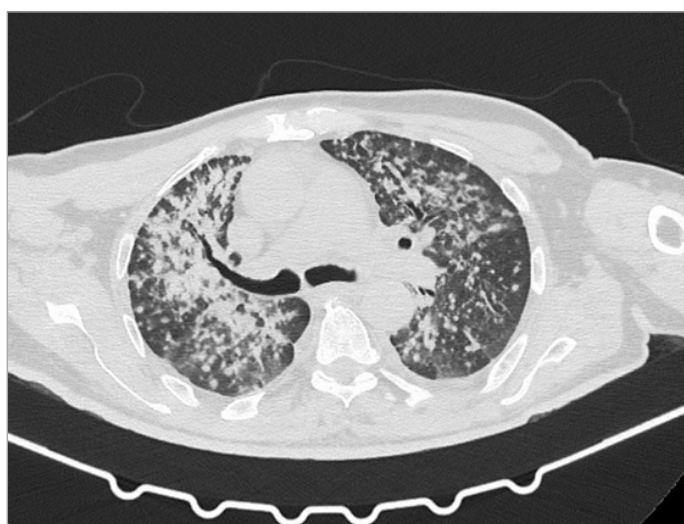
Lymphangitic carcinomatosis in CT scan.
